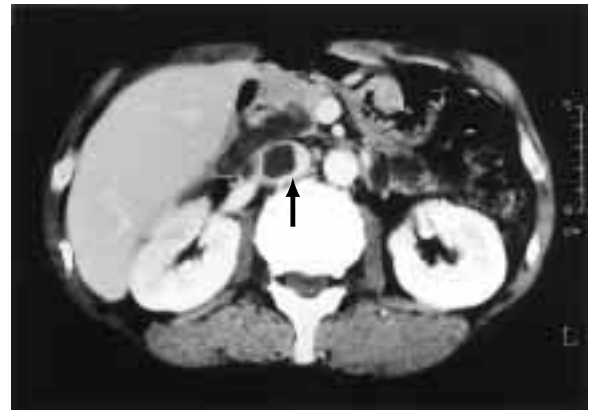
Enhanced abdominal CT revealed IVC thrombus (*arrow*) and cystic mass adjacent to the IVC (*open arrow*). This cystic mass was considered pancreatic complicated cyst.
